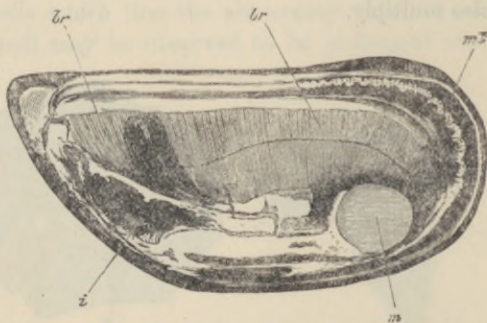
VALVE OF MUSSEL (*MYTILUS EDULIS*) SHOWING *br, br*, THE EXPANDED GILLS OR BRANCHIÆ, WHICH, OWING TO THE LITTLE BARS OF WHICH THEY ARE COMPOSED, PRESENT A STRIATED ASPECT.
